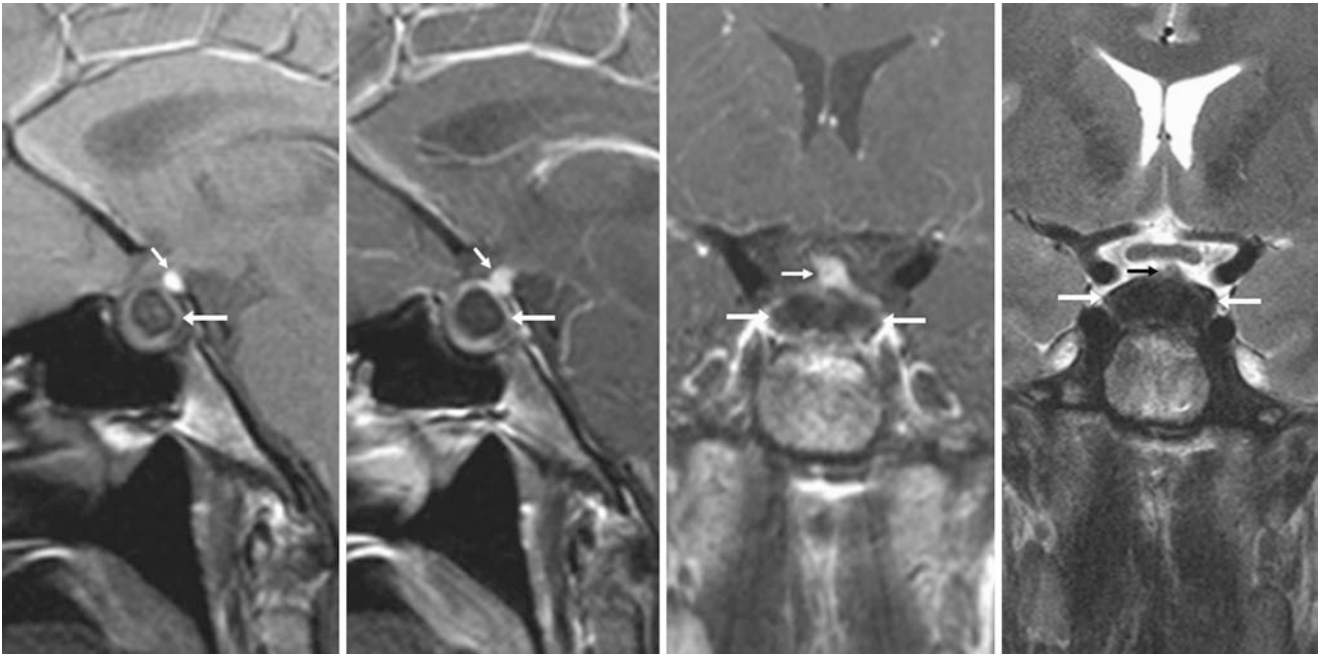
The patient was a 39-year-old female with hypogonadism. A 3 T MRI demonstrated a 11×19 mm T1- and T2-dark RCC (*arrows*) that replaced most of the gland and compressed the stalk (*thin arrows*) superiorly on noncontrast sagittal T1WI (*left*), on postcontrast sagittal
